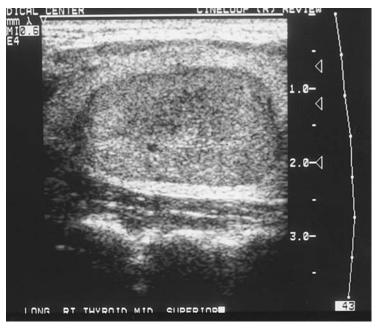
Thyroid ultrasonography may help to localize lesions and improve adequacy of fine-needle aspirates.
